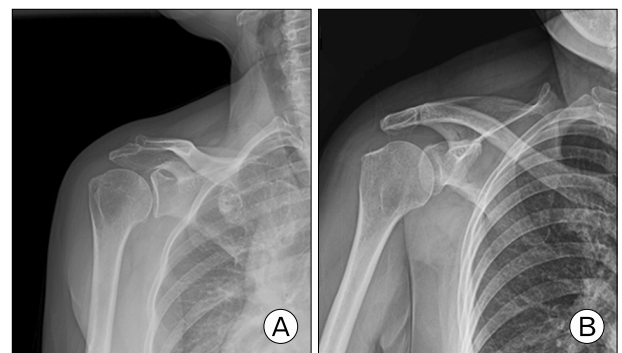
Plain radiographs of the right shoulder. (A) Antero-posterior and (B) 20° caudal tilting view.
